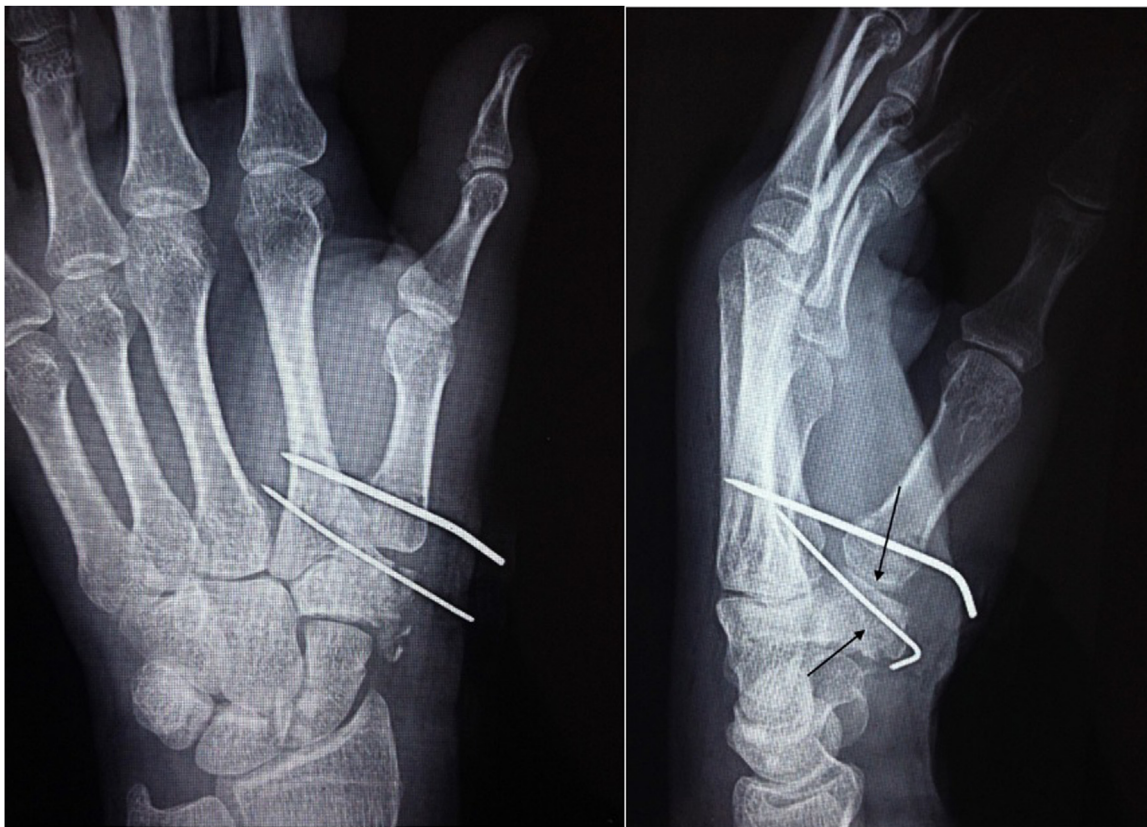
Postoperative radiographs show a suitable reduction of the 1st carpometacarpal articular surface. Black arrows display the fracture line.
